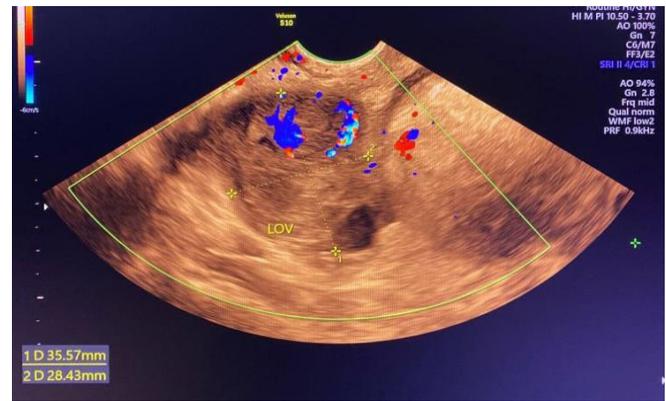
Transvaginal ultrasound showing a left complex mass of 28 x 35mm
